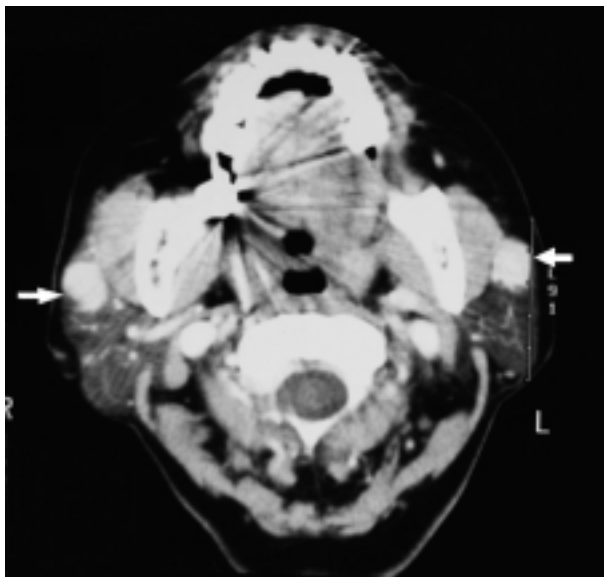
CT exam showed heterogeneous enhancement, and hyperintensive tumors located in the anterior superficial portion of the bilateral parotid glands.
